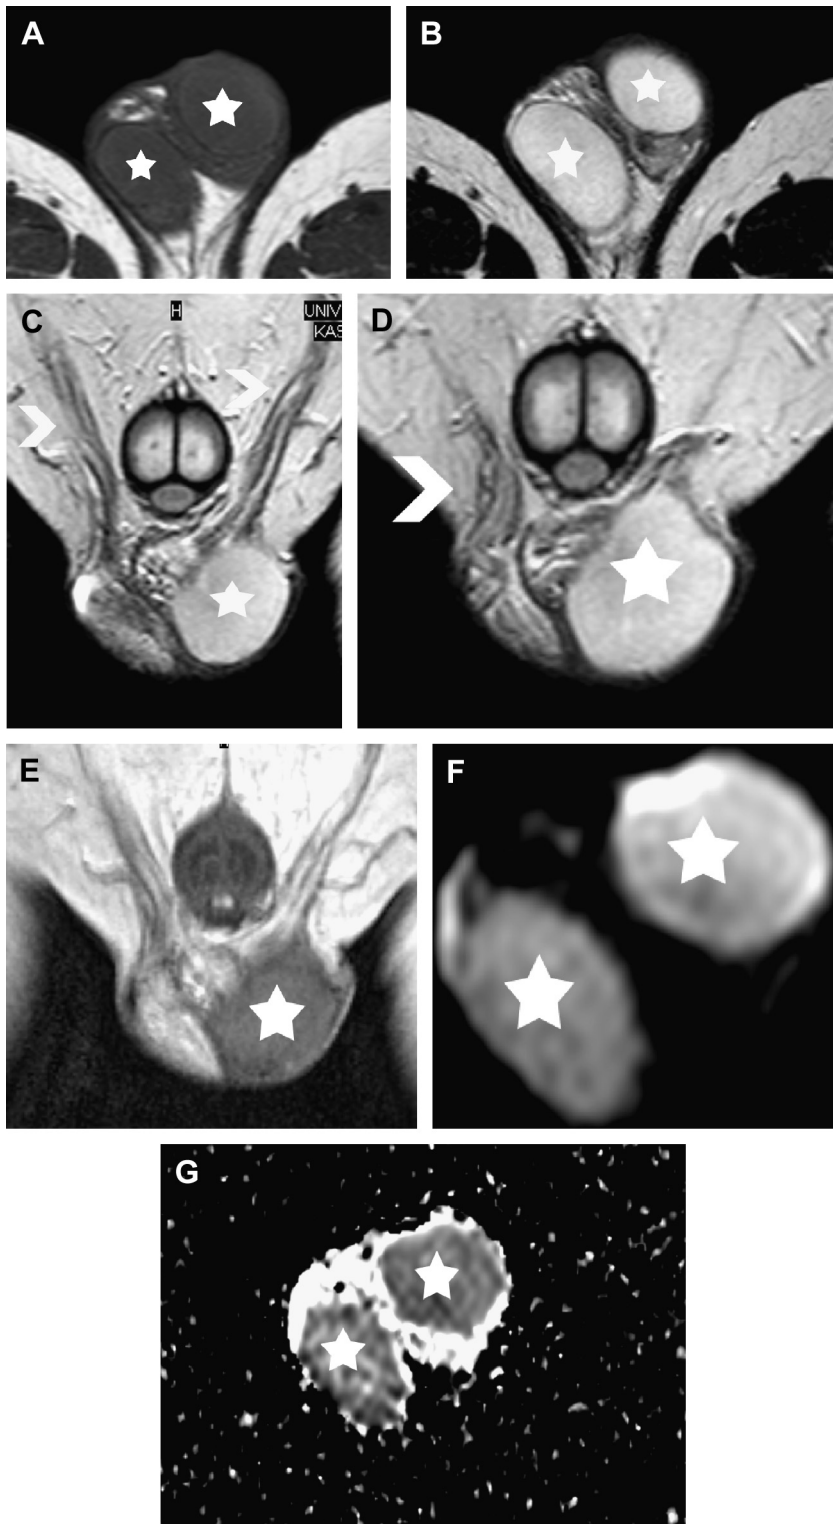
Normal MR imaging examination of the scrotum in a 36-year-old man. (A) Transverse T1-weighted image shows normal testes (*asterisks*), with signal intensity similar to that of the surrounding muscles. (B) Transverse T2-weighted image. Normal testicular parenchyma (*asterisks*) appears hyperintense. The testes are surrounded by a thin hypointense halo, corresponding to tunica albuginea. (C, D) Coronal T2-weighted images show normal appearance of both spermatic cords (*arrowheads*). Normal left testis (*asterisk*). (E) Coronal DCE image depicts homogeneous enhancement of normal testicular parenchyma (*asterisk*). (F) Transverse DW image ($b = 900 \text{ s/mm}^2$) depicts normal testes (*asterisks*) with high signal intensity. (G) The ADC values of normal testes (*asterisks*) are $1.04 \times 10^{-3} \text{ mm}^2/\text{s}$ (right testis) and $1.01 \times 10^{-3} \text{ mm}^2/\text{s}$ (left testis).
